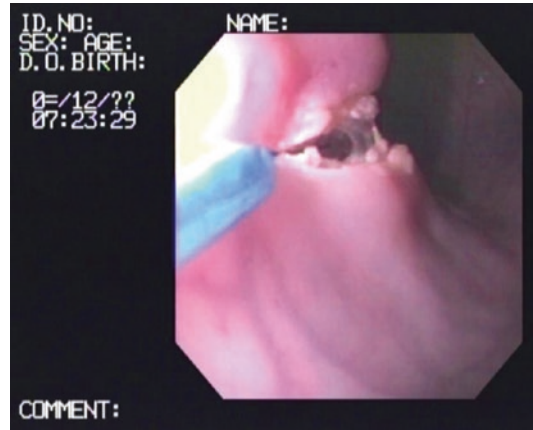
Endo-knife incision through greater curvature of stomach into cyst, having injected adrenaline and employed endo-ultrasound to avoid gastric vessels
